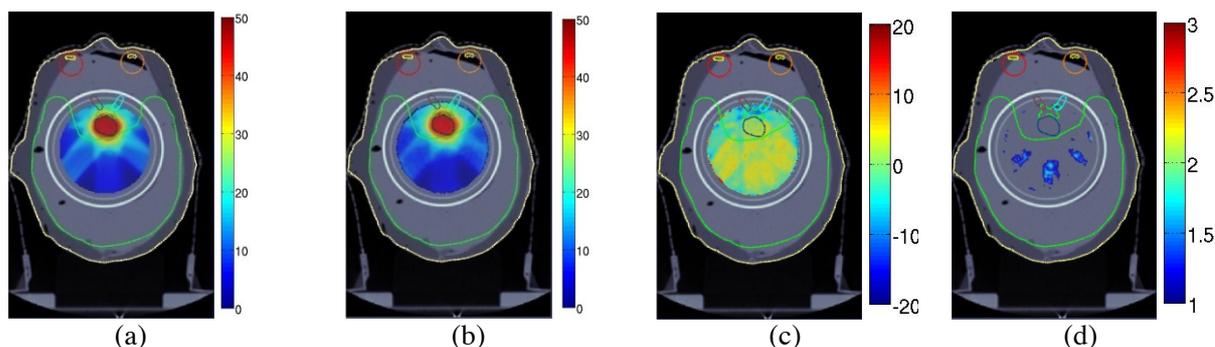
The dose distribution of the TPS (a), the gel measurement (b), the difference map between the TPS and gel (expressed in percent) (c) and a gamma map (3%/3mm, d) are shown as an overlay figure on the CT images at the level of the isocentre. Anatomical structures are shown: cerebrum, eyes, eye lenses, optical nerves, optic chiasm, PTV and CTV.
